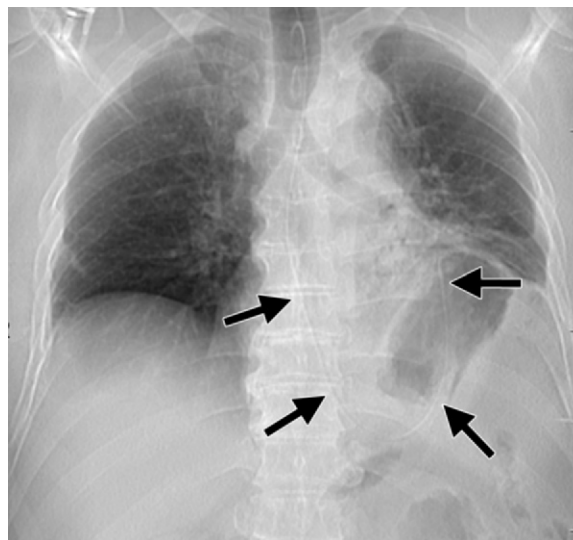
Chest radiograph shows features highly suggestive of left-sided BDR in a 55-year-old man: a markedly elevated left hemidiaphragm; basal consolidation of the left lung; and a nasogastric tube deformed into a U shape, with its distal extremity located above the expected level of the left hemidiaphragm (arrows). Left-sided BDR was found at subsequent CT and confirmed at surgery.
